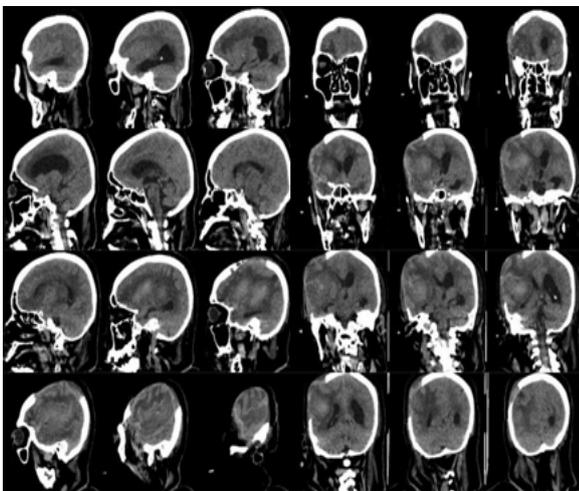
Patient's CT Image
